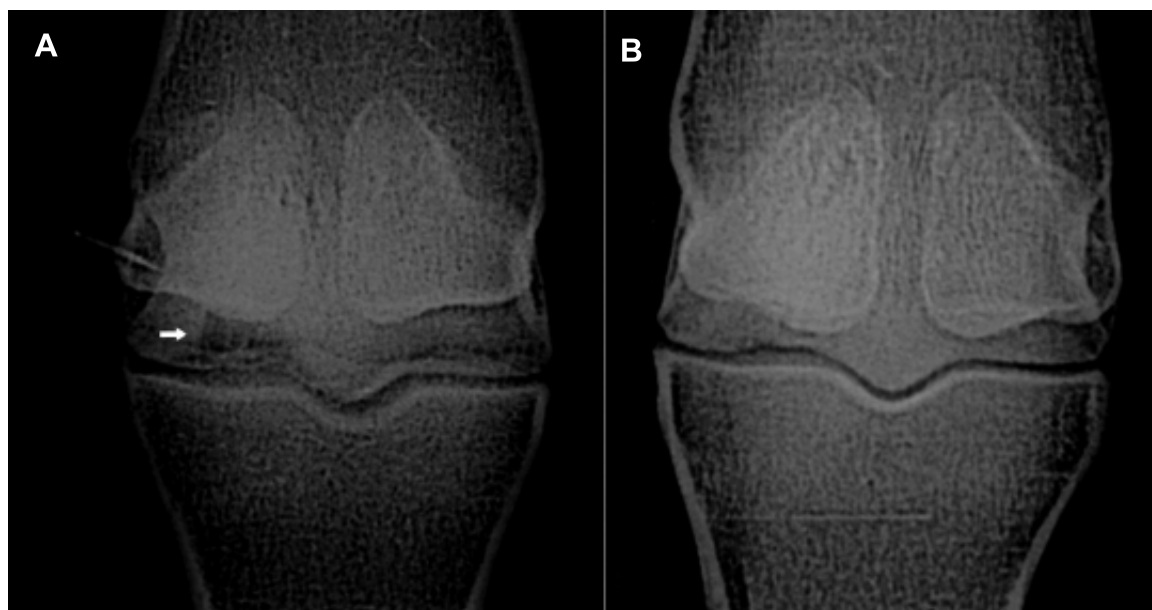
Radiographic appearance of a subchondral cystic lesion in distal epiphysis of Mc III in thoroughbred colt before (A) and 5 weeks after surgical treatment (B) with the method described. Radiographs performed in a dorso-plantar projection. Lucent, flat cystic lesion marked with an arrow on intra-operative radiograph (A).
